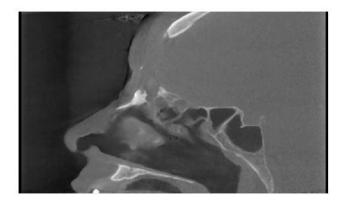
Sagittal image for 18 months post-operative CT scan.
